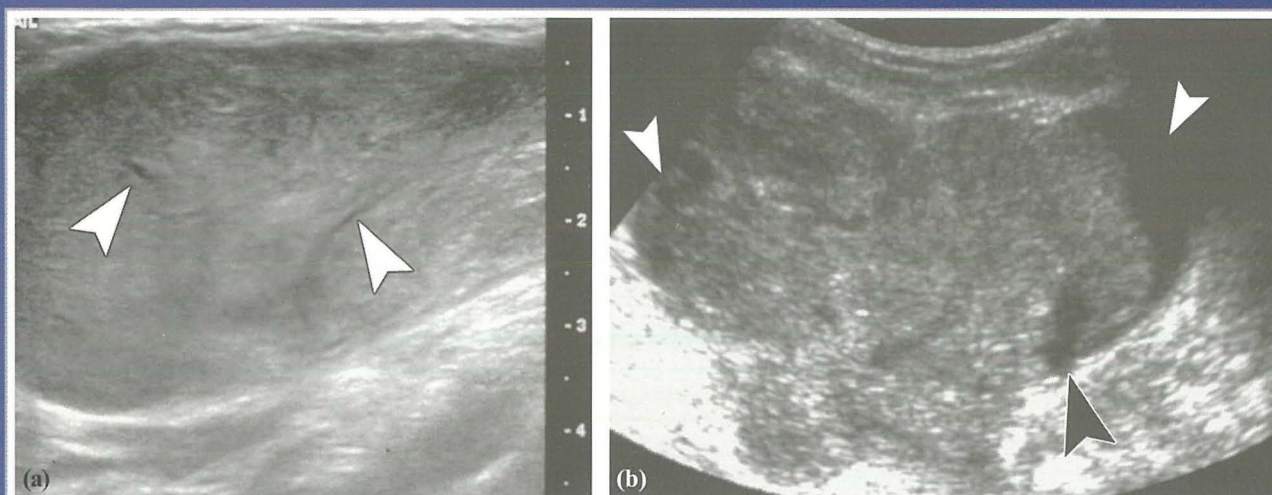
(a) Ultrasound scan of a benign phyllodes tumour reveals a fairly homogeneously hypoechoic, sharply circumscribed mass with dorsal enhancement and anechoic linear clefts (arrowheads). These findings are similar to the appearance of a juvenile fibroadenoma. (b) Ultrasound scan of a malignant phyllodes tumor reveals a partially circumscribed hypoechoic mass with posterior sound enhancement and anechoic foci (arrowheads), some of which are round and others are curvilinear.
